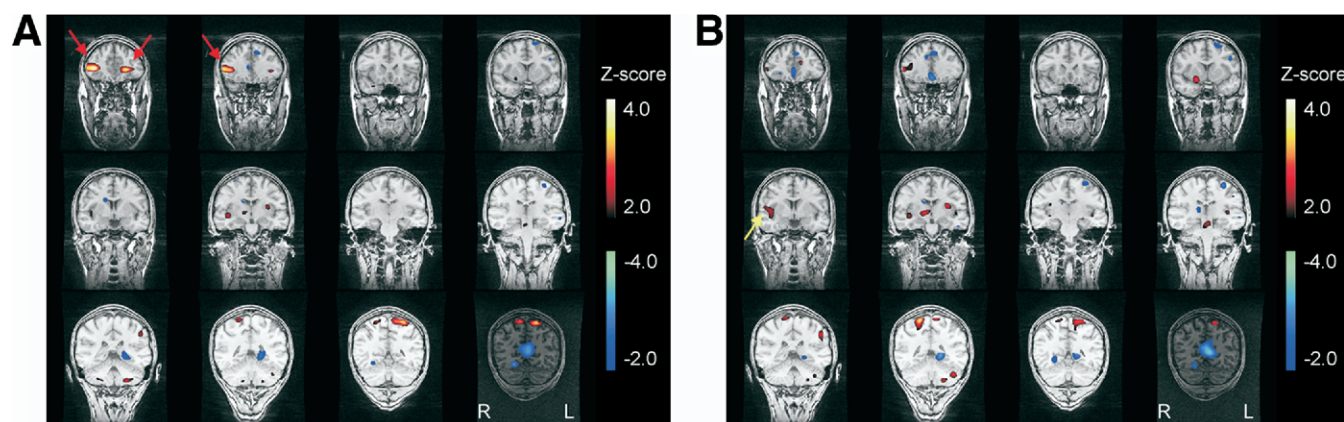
SISCOM images before (A) and after (B) correction for movement during scanning. The foci of ictal hyperperfusion present bilaterally over the inferofrontal cortex (red arrows) on SISCOM (A) were the result of a movement artifact during acquisition and thus false positive. These findings were discordant with the electroclinical suspicion of an ictal onset zone in the right temporal neocortex in this patient with refractory partial epilepsy and normal MRI scan of the brain. All her seizures began with buzzing in the ears, followed by paraesthesia in the left limbs. After movement correction, these clusters were no longer present. A cluster of ictal hyperperfusion was present in the right insular to high temporal cortex (yellow arrow in B), which is concordant with the hypothesis of ictal onset in the right temporal neocortex. The largest and most intense cluster in the right parietal lobe at the midline could be explained by propagation. The referring neurologist planned further depth-EEG studies. The ictal SPECT injection was given during a complex partial seizure that lasted around 200 seconds, with initiation of the injection 18 seconds after seizure onset.
